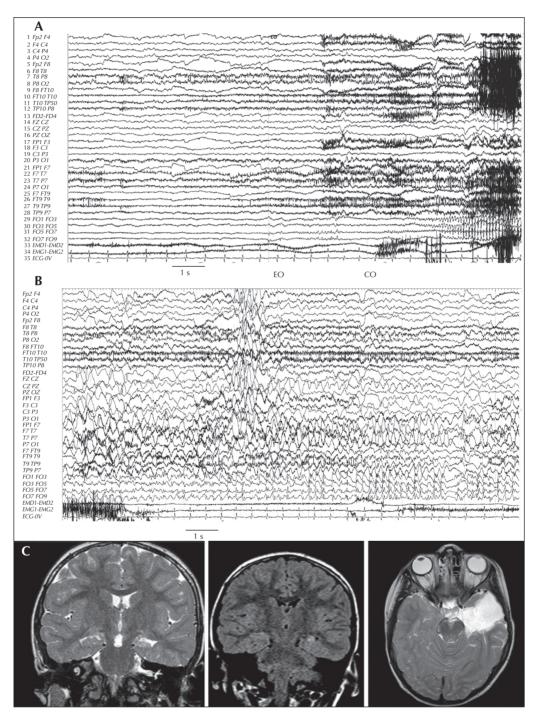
Patient 26. (A, B) Ictal EEG with FOE (longitudinal montage with supplementary temporo-basal electrodes, the electrode FO 1 being the most posterior) (see video sequence 8). (A) Electrical onset (EO) at the anterior contacts of FOE; the child says that she is having a seizure. CO: clinical onset. (B) Seizure continuation showing spike-and-wave discharge on both temporal electrodes and FOE; the discharge is faster on FOE. (C) Preoperative MRI showing polar and temporo-basal white/grey matter blurring with hippocampal sclerosis and postoperative follow-up.
